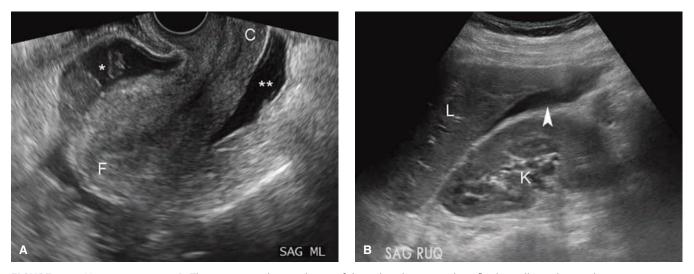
Hemoperitoneum. A. This transvaginal sagittal view of the pelvis shows anechoic fluid initially pooling in the retrouterine cul-de-sac (). Large accumulations will also extend into the anterior cul-de-sac (*). B. In this right upper quadrant sonogram, anechoic fluid is seen in Morison pouch (*arrowhead*). C = cervix; F = fundus; K = kidney; L = liver. (Reproduced with permission from Dr. Devin Macias.)
